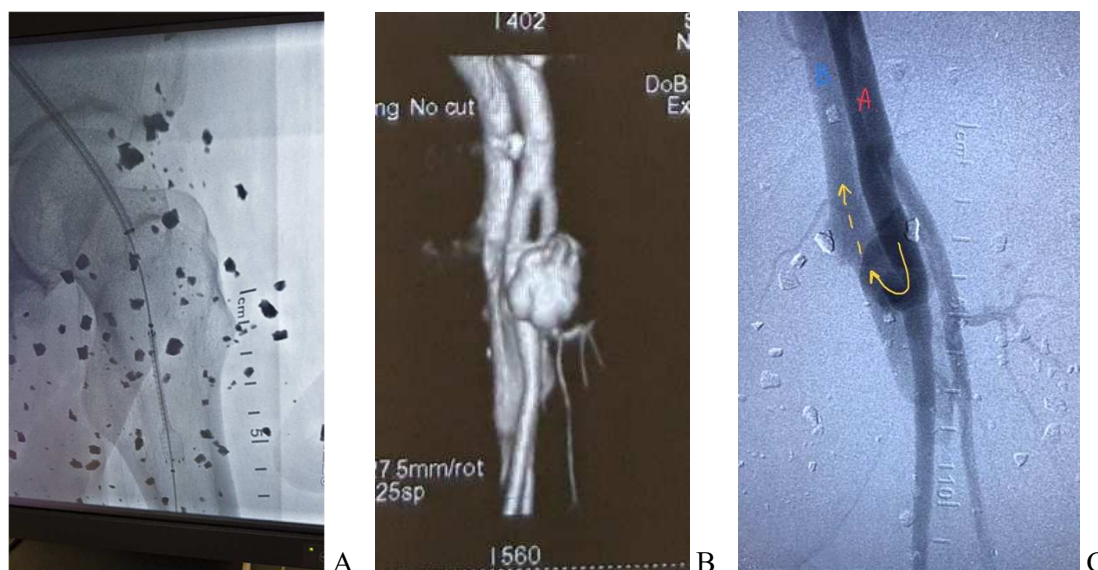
Mine explosion injury in a serviceman with CGWMVLE, where: a – X-ray imaging of fragments, b – functioning post-traumatic arteriovenous fistula between the common femoral artery and vein (MSCT with contrast), c – stent-graft stenting operation of AB-fistula.
